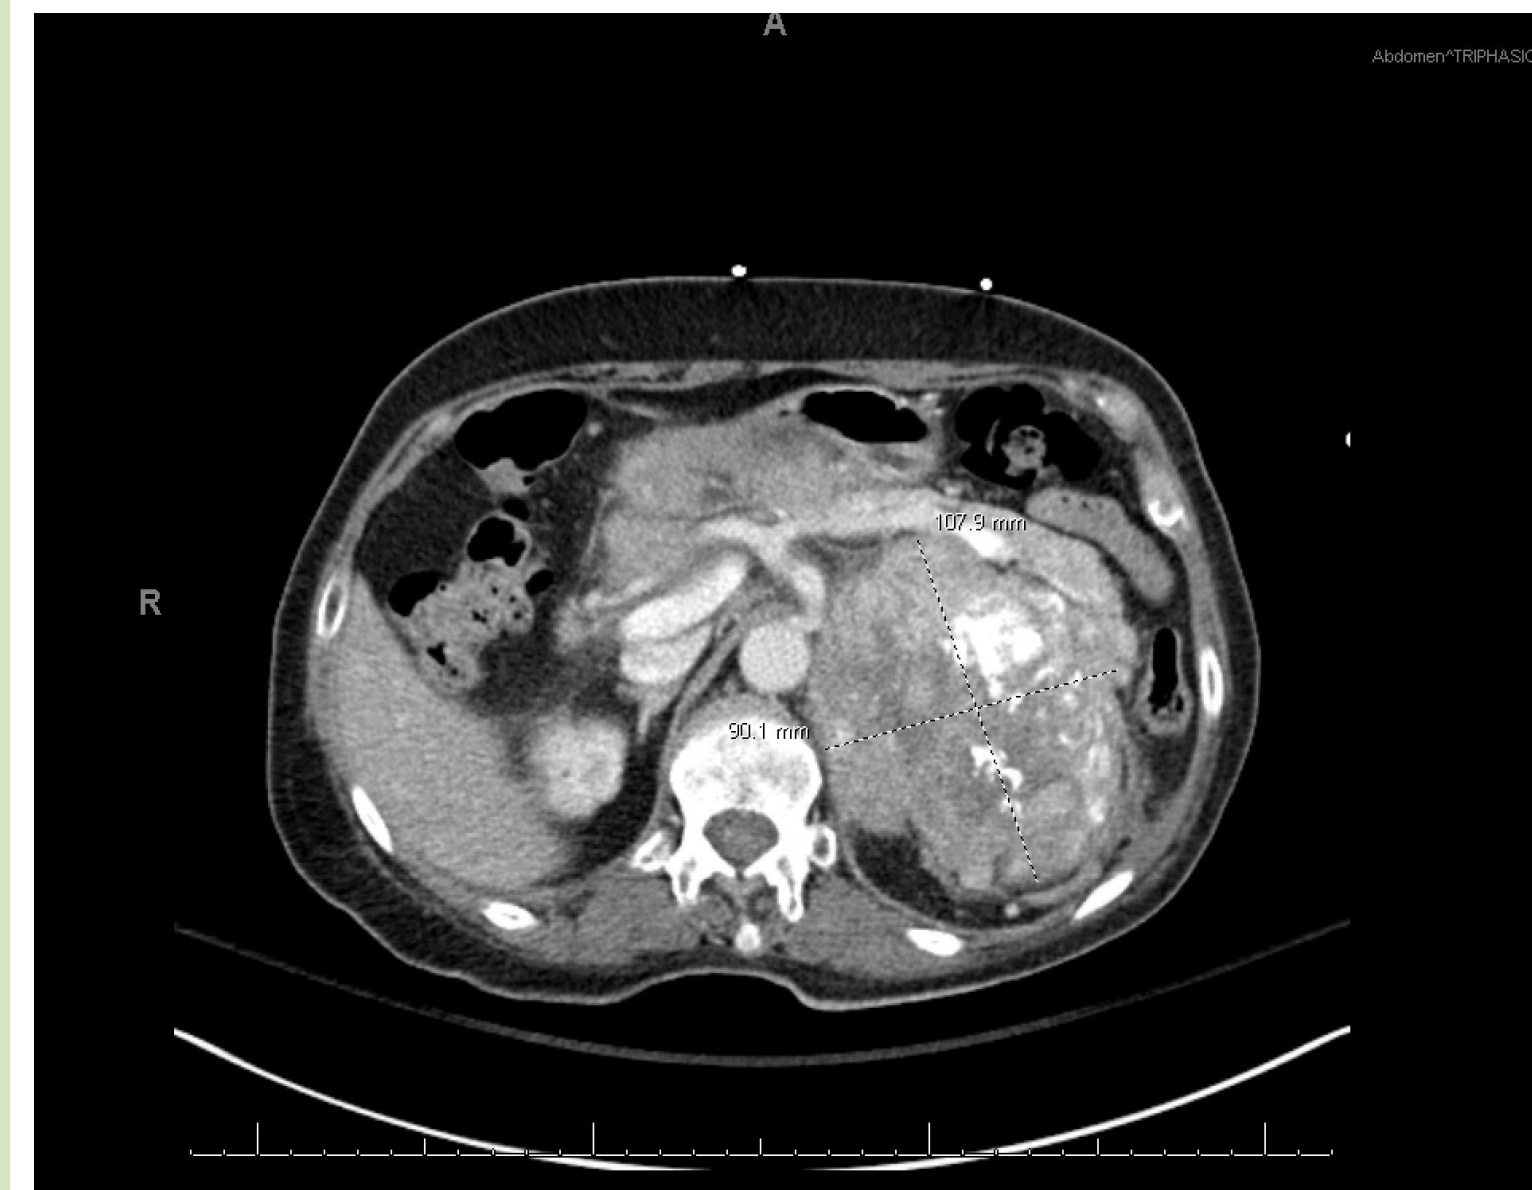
CT Abdomen and Pelvis showing 2 heterogenous masses 11.2 x 7.7 cm and 12.1 x 9.7 cm left adrenal mass.
